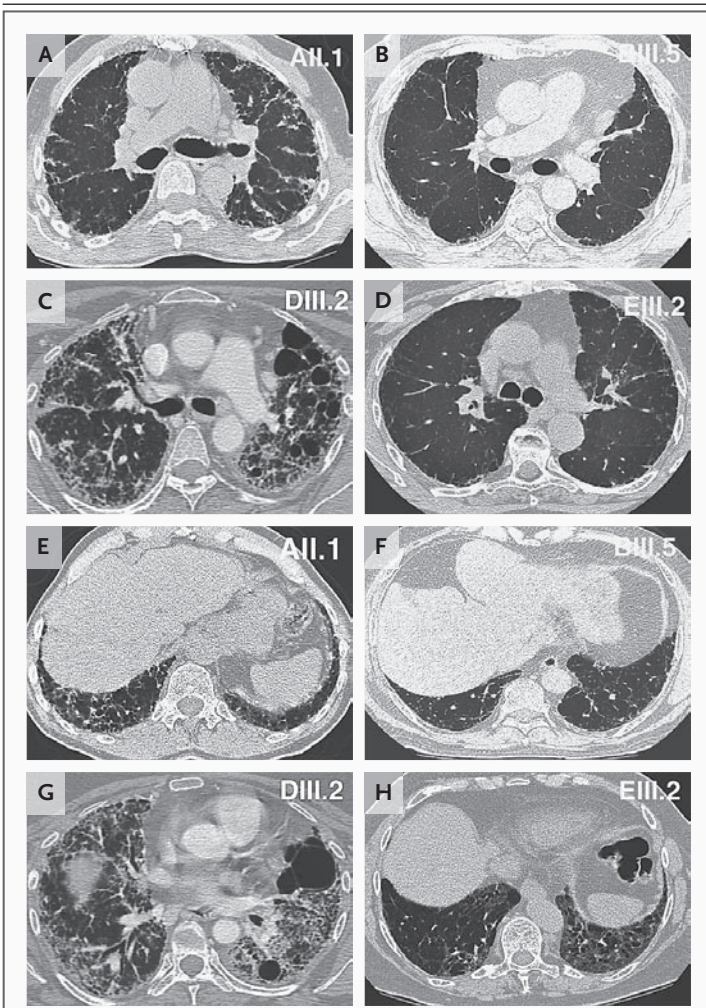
High-Resolution Computed Tomographic Images of the Midlung (Panel A through Panel D) and Bases (Panel E through Panel H) in Probands in Four Families.
